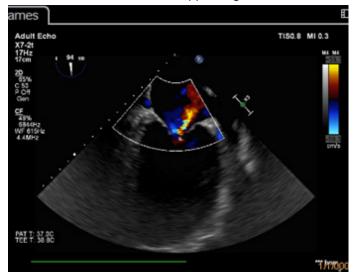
Transesophageal echocardiography. Midesophageal view at 90 degrees. Color Doppler shows mitral regurgitation in a patient with moderate dilation of left atrium.
